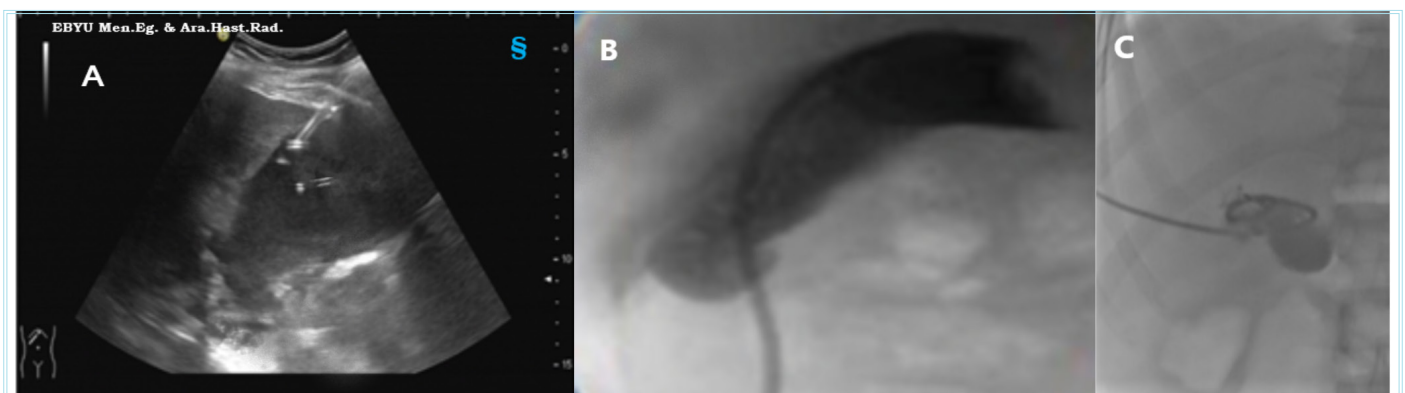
Techniques used for TP or TH percutaneous cholecystostomy. Application of TP or TH percutaneous cholecystostomy under ultrasonography (A) and fluoroscopic guidance (B, C). Placement of 8- and 10-Fr multihole pigtail indwelling drainage catheters after successful confirmation of gallbladder lumen by percutaneous puncture and contrast injection
